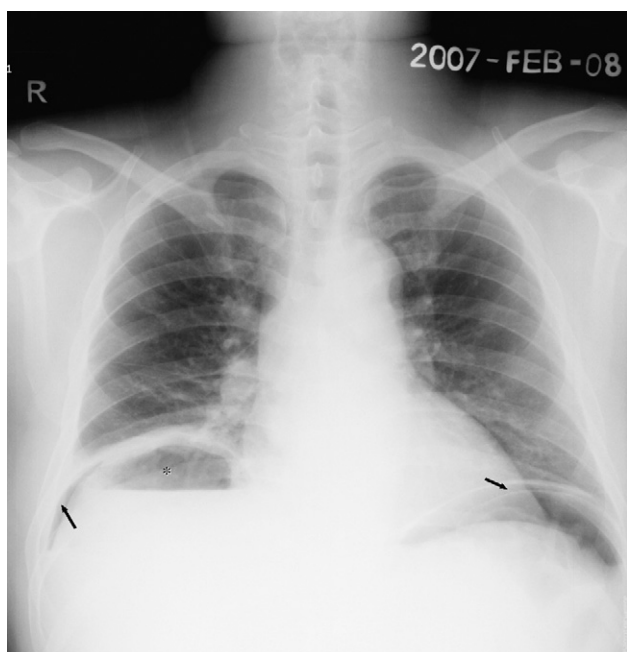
Chest X-ray showing pneumoperitoneum (black arrow) and an abnormal gas collection with an air-fluid level (*) in the right subphrenic region.
